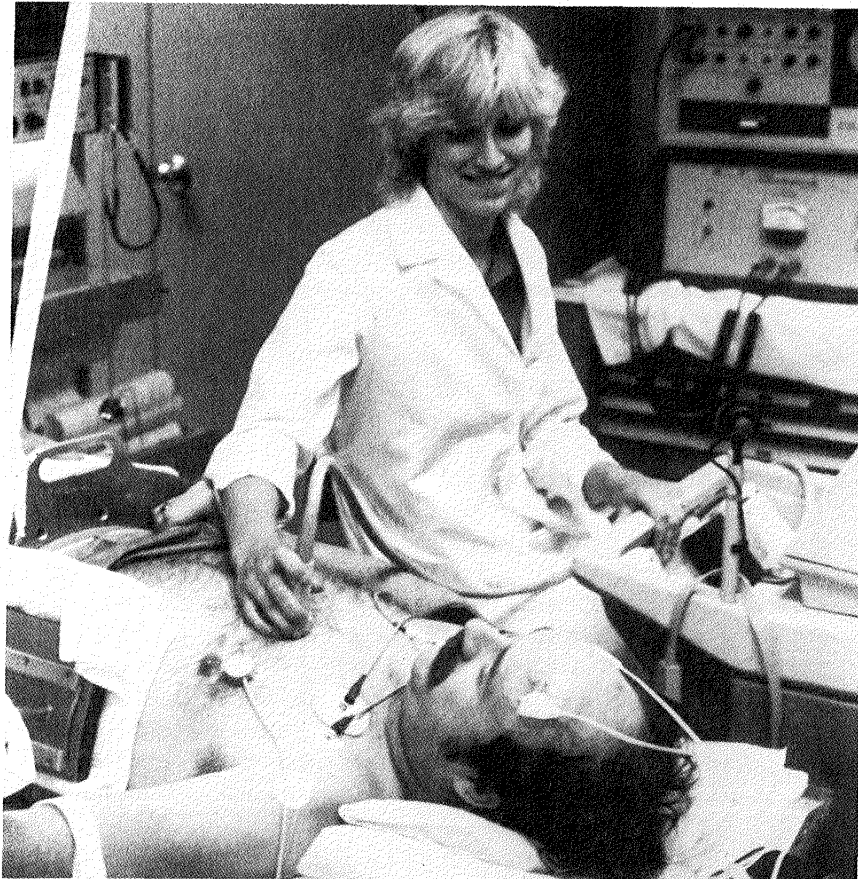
Bedrest subject undergoes echocardiography during lower body negative pressure (LBNP), analogous to Shuttle crew postflight echocardiography. (Popp 199-10-22-10)
